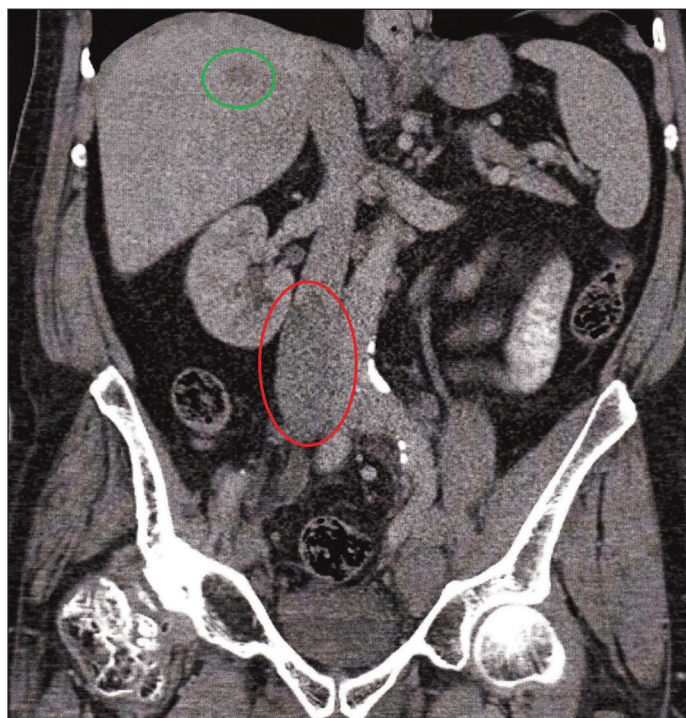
Contrast enhanced abdominal CT scan: sagittal section. This image demonstrates the ovoid hypodense filling defect in the expanded infra-renal IVC (red circle). Note also the low attenuating metastatic deposits in the liver (green circle).
